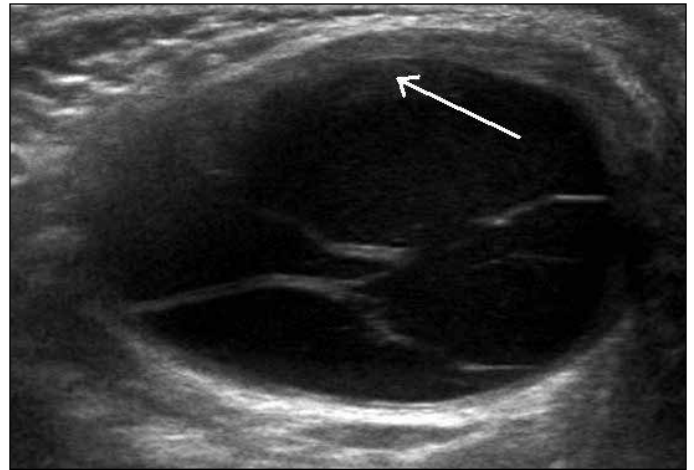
Ultrasonography of the right testis showing a cystic mass with septations. A rim of testicular tissue was present (arrow).
